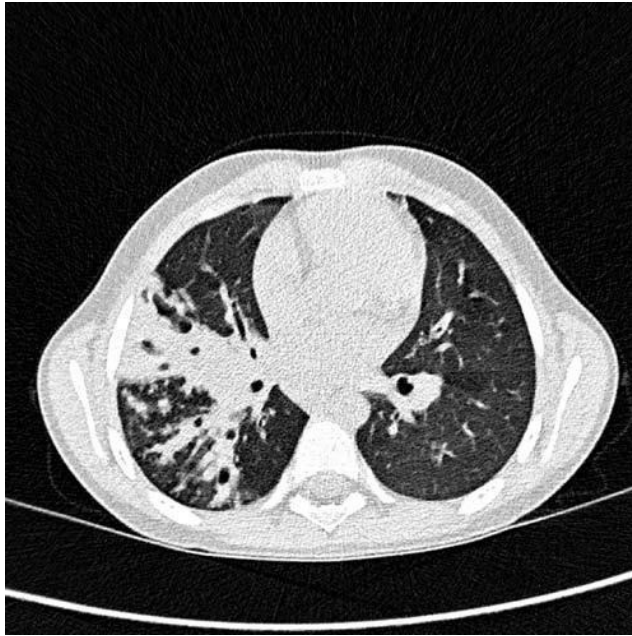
Chest HRCT scan of an 7-year-old-boy with AI and CF shows patchy consolidation in segments 4 and 6 of the right lung and bronchiectasis with mucous plugs. After ineffective antifungal treatment the patient had lower right bilobectomy performed. (CT was performed in the Department of Diagnostic Imaging of Institute of Mother and Child in Warsaw).
